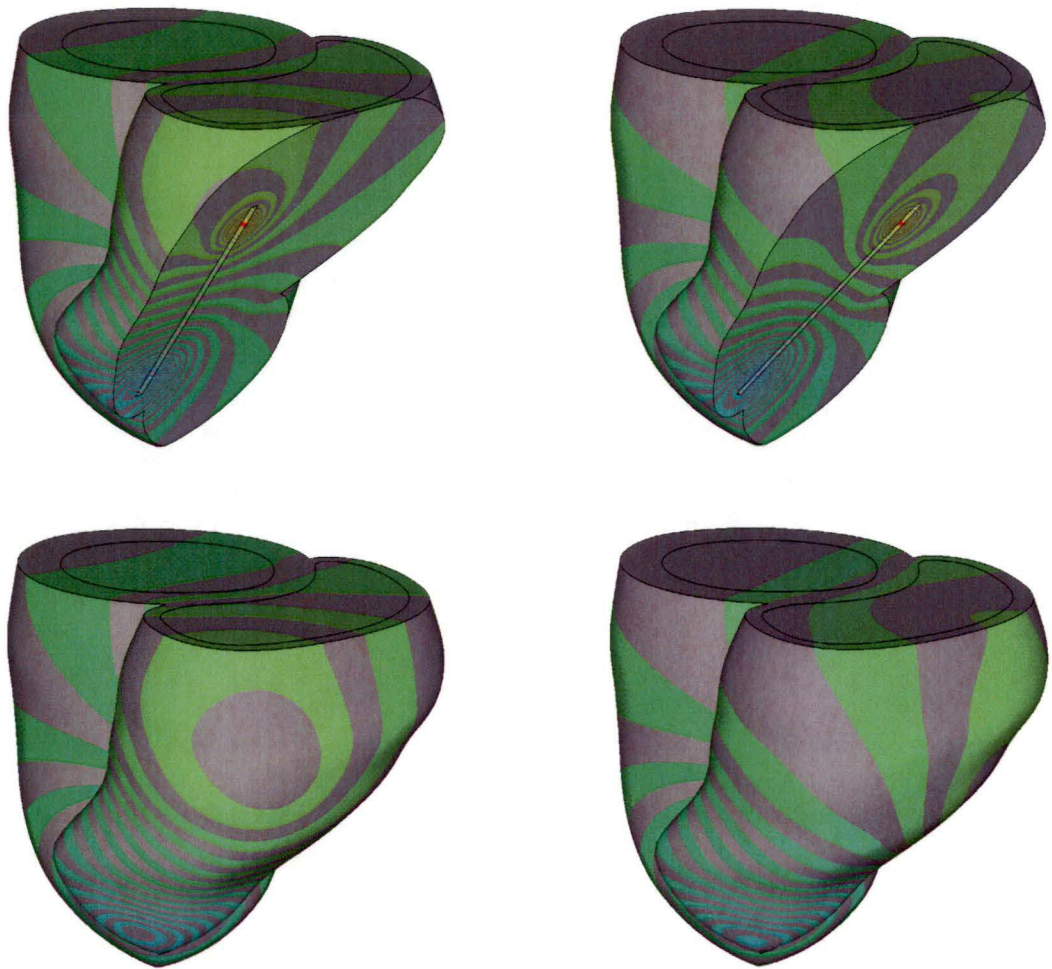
Off centre (liver - pulmonary artery direction) right ventricle catheter voltage contours in tagged MRI model at end diastole for blood conductivity/myocardium conductivity = 2.75.
